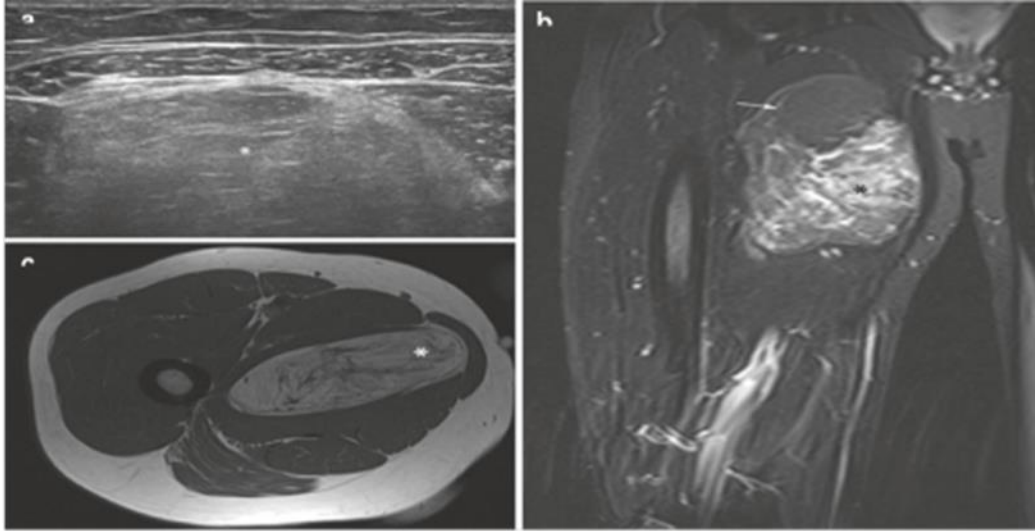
Well-differentiated liposarcoma of the right thigh. (a) Ultrasound. (b) Coronal fat-suppressed SE T2-weighted MR image. (c) Axial SE T1-weighted MR image [28].
